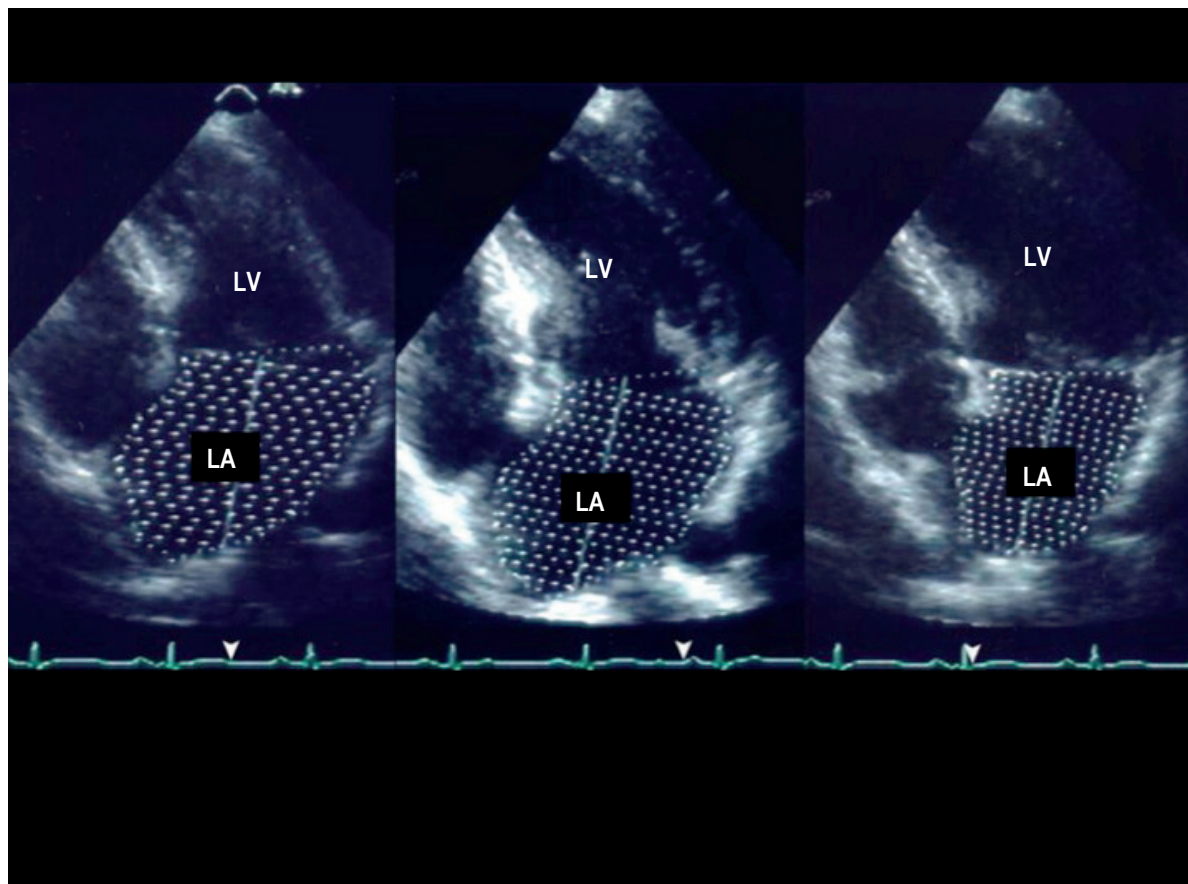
Apical 4-chamber view showing the measurements of left atrial maximum, pre A and minimum volume. LA: left atrium; LV: left ventricle.
